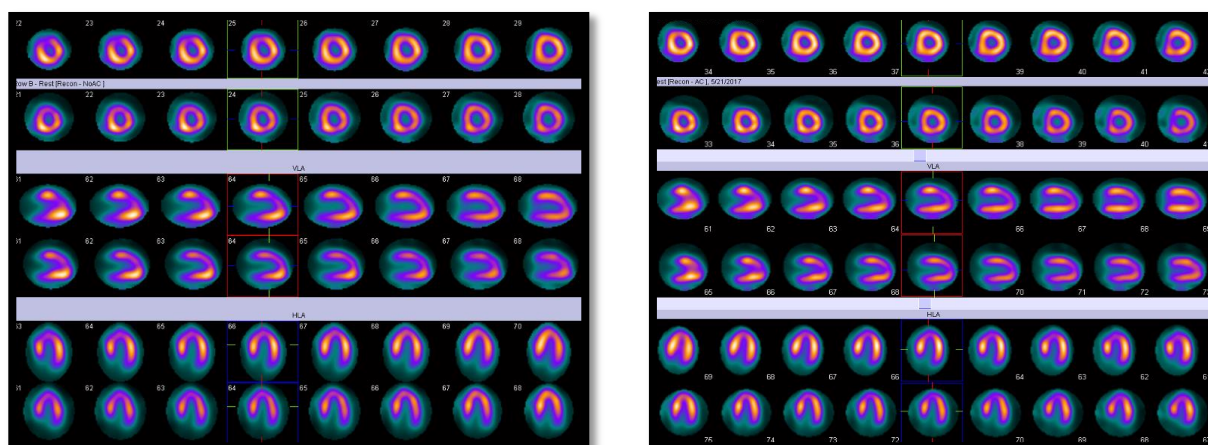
50 year-old female patient with atypical chest pain, normal echo and coronary angiography showed no significant stenosis. (a) Gated MPS shows medium sized reversible perfusion defect in the antero-septal region, however the final clinical diagnosis was negative for true ischemic perfusion defect which is not confirmed in the CT-AC images (b) the CT-AC images shows partial improvement of the perfusion defect in the antero-septal region (FP result).
